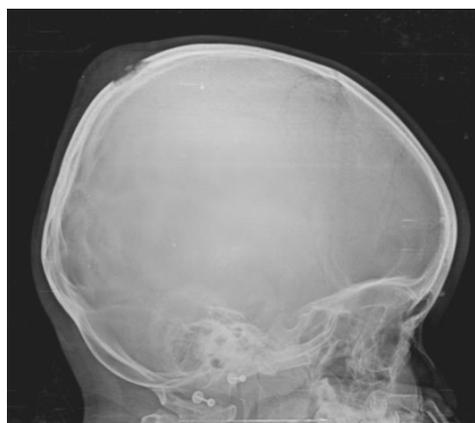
Skull radiograph - lytic lesion of the parietal bone, with surrounding edema of the adjacent soft tissues.
